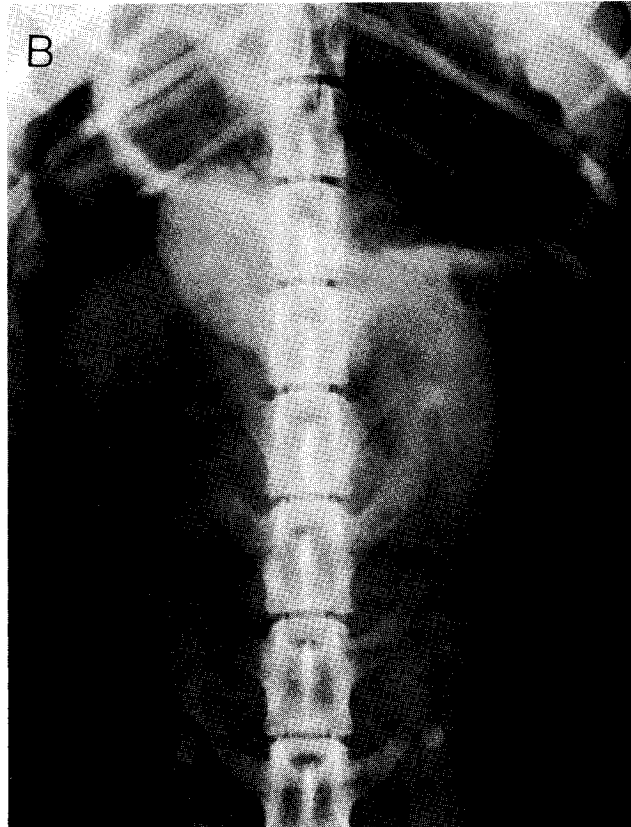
(A), Abdominal scan (1 mCi of ^{99m}Tc Na pertechnetate 24 hr after surgical production of jejunal intussusception) obtained 30 min after intravenous injection of radiopharmaceutical. Normal accumulation in the stomach of radioactive substance as well as abnormal radioactivity just inferior to the stomach. (B), Abdominal radiograph: Soft tissue density just below gas filled stomach was found at surgery to represent jejunal intussusception.
